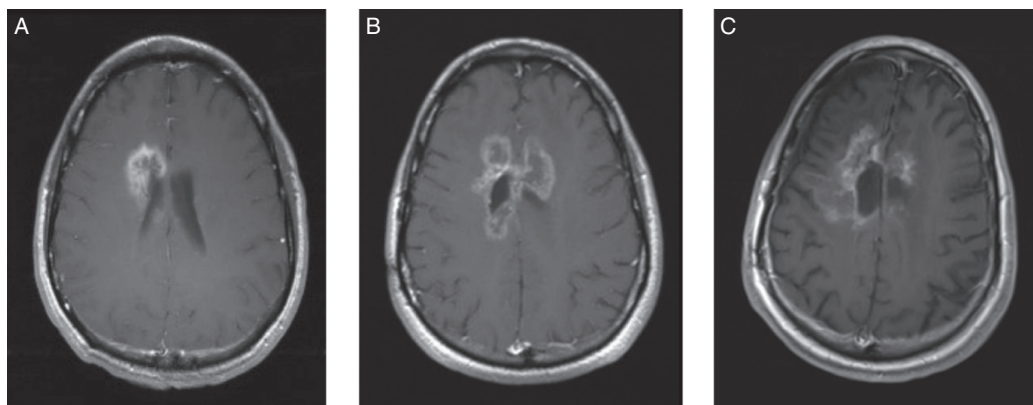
Progressive treatment necrosis (A–C; T1-weighted gadolinium-enhanced axial MRI sequences). (A) A 35-year-old male with right frontal low-grade astrocytoma (World Health Organization grade II) underwent surgical resection followed by TMZ-based chemo-RT treatment. Eight months post-RT completion he developed headaches of increased frequency and was found to have a new nodular focus of enhancement in the right frontal lobe subjacent to the resection cavity, with periventricular and corpus callosum involvement, a biopsy of which revealed TN. (B) Sequential TMZ was resumed and completed over the next 6 months; however, the patient experienced worsening of his symptoms as the region of enhancement continued to expand. (C) Despite initiation of corticosteroid and bevacizumab treatment, he developed progressive left-sided hemiparesis and cognitive decline over the following 2 years, prompting a second biopsy of the continually enhancing lesion, which again confirmed TN. Therapeutic management of symptomatic TN was continued; however, the patient deteriorated further, necessitating a transfer to hospice care, where he eventually passed away 2 years after the second biopsy.
